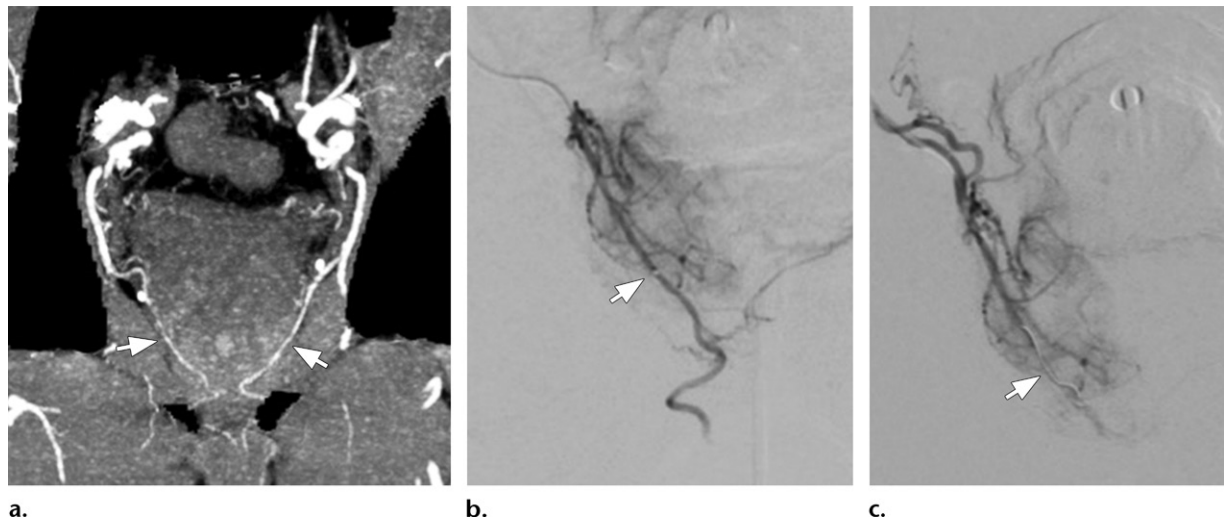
Coil embolization to protect from nontarget embolization. (a) Coronal cone-beam CT image shows accessory IPAs (arrows) that must be addressed to avoid nontarget embolization. (b) Arteriogram shows the microcatheter (arrow) used to select the nontarget vessel arising from the right PA. (c) Arteriogram after placement of a metallic coil (arrow) shows occlusion of the accessory IPA. Embolization was performed safely.
